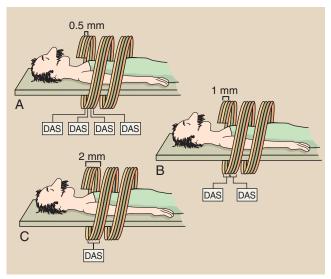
A four-slice helical computed tomography scan allows changes to be made in slice thickness. A, Four slices of 0.5 mm each. B, Two 0.5-slices can be combined to make two 1-mm slices. C, Four 0.5-mm slices can be combined to make one 2-mm slice. *DAS*, data acquisition system.
